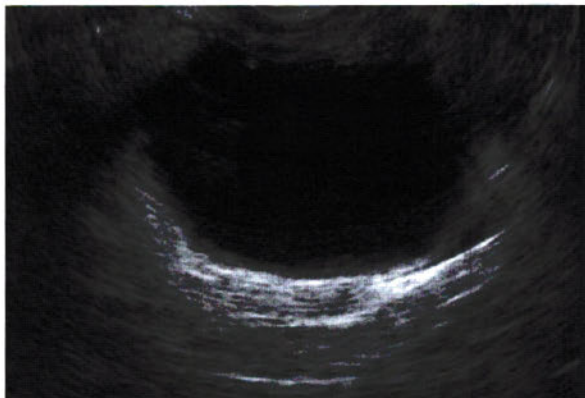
Ultrasound Showing Pancreatic Pseudocyst
